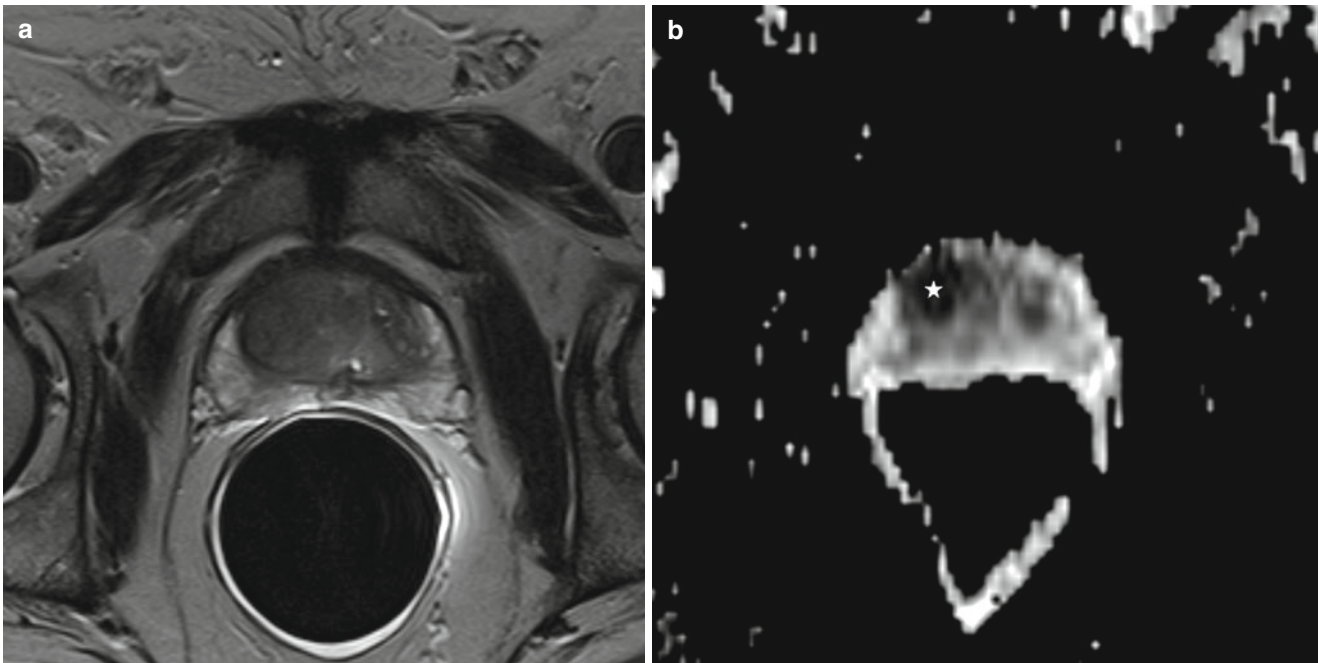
A 71-year-old patient with prostate cancer in the central gland. On a transverse T2W image, the central gland shows normal diffuse heterogeneously low signal intensity, without suspicious lesions (a). On DWI (b, at the same level as a), strikingly low ADC values are
